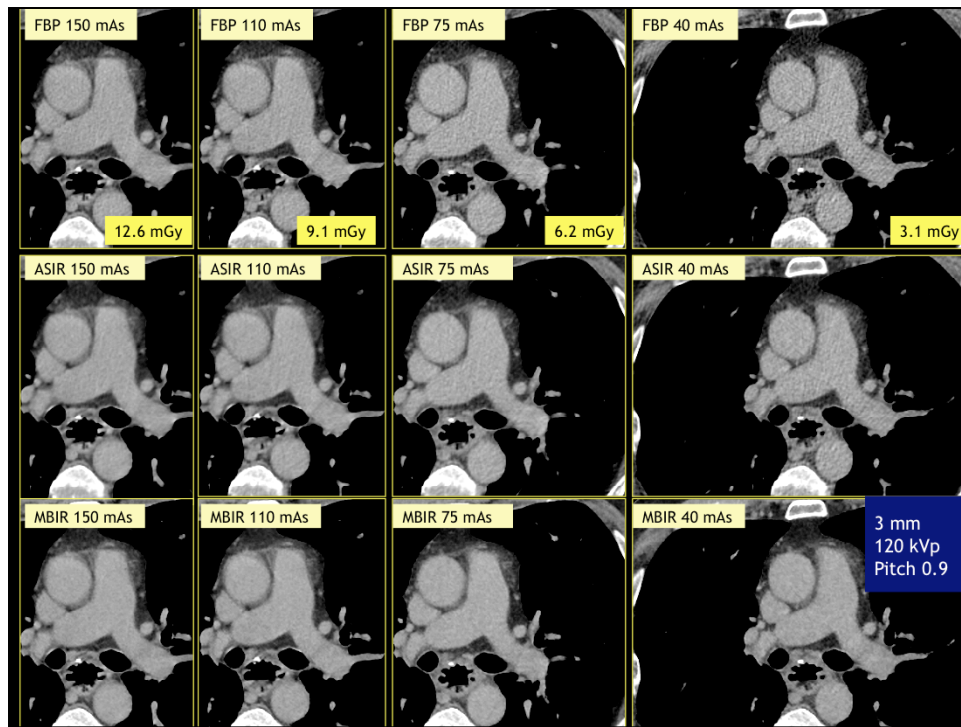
Transverse chest CT images (mediastinal windows) acquired at four tube current levels (150, 110, 75 and 40 mAs) were reconstructed with FBP (top row) and two iterative reconstruction techniques [Adaptive Statistical Iterative Reconstruction, ASIR (middle row) and Model Based Iterative Reconstruction, MBIR, GE Healthcare (bottom row)]. Both ASIR and MBIR enabled images show lower image noise at all dose levels, except at the lowest radiation dose (3.1 mGy), ASIR technique has lower image noise compared to FBP, whereas MBIR image has the lowest image noise (even when compared to the 150 mAs FBP image).
